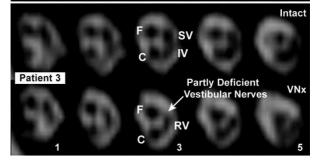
(A) Axial high resolution MR image curved reformatted along the vestibulocochlear nerve pathway in the IAC on the VNx and intact sides. (B) Orthogonal MR images reformatted along the vestibulocochlear nerve axis in the IAC in five 0.8 mm contiguous slices in Ménière's Patients 1, 2 and 3. Sections from the intact side have been reflected for ease of comparison between the VNx and intact sides. On the intact side, the facial (F), cochlear (C), superior vestibular (SV) and inferior vestibular (IV) nerves were observed. In Patient 1 who was asymptomatic post-VNx, only the facial and cochlear nerves are present on the VNx side with superior and inferior vestibular nerves completely absent. In symptomatic Patient 2, the superior and inferior vestibular nerve appeared to have deficient bulk and signal, with some residual vestibular (RV) nerve bulk still present. In symptomatic Patient 3, the superior vestibular nerve was absent, while the inferior vestibular nerve appeared almost intact with similar bulk and signal to the intact side.
